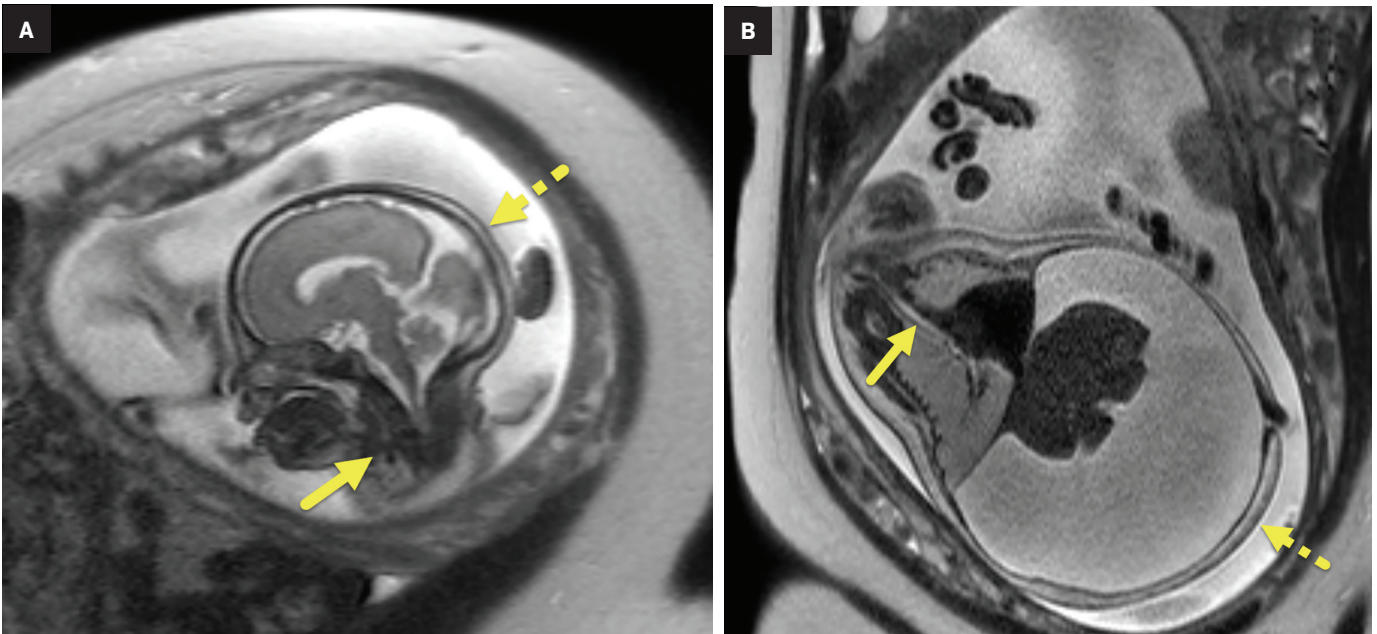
(A) MRI of the fetal brain and neck demarcates the atresia (arrow) of the cervical trachea indicated by the absence of fluid signal. Scalp edema (dashed arrow) results from the hydrops. (B) MRI obliquely through the fetal chest and abdomen demonstrates the dilated thoracic trachea (arrow), enlarged lung, eversion of the diaphragm, marked ascites, and skin edema (dashed arrow) from hydrops.
